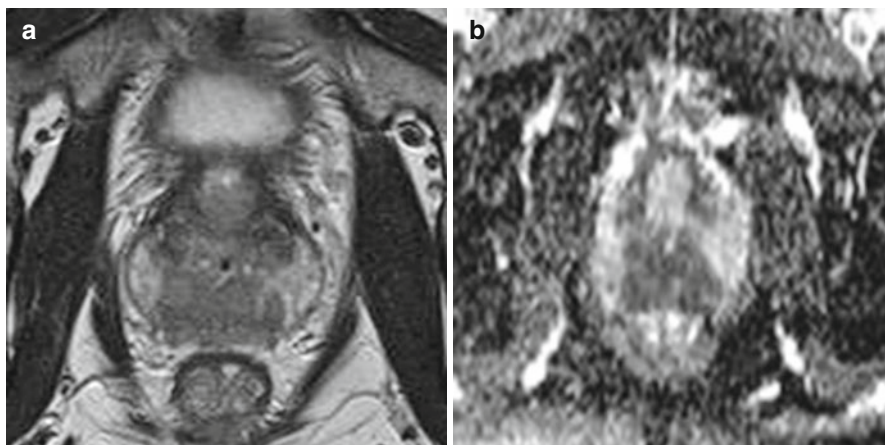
Peripheral gland tumour on T2 MRI (a) and on DWI-MRI (b)
